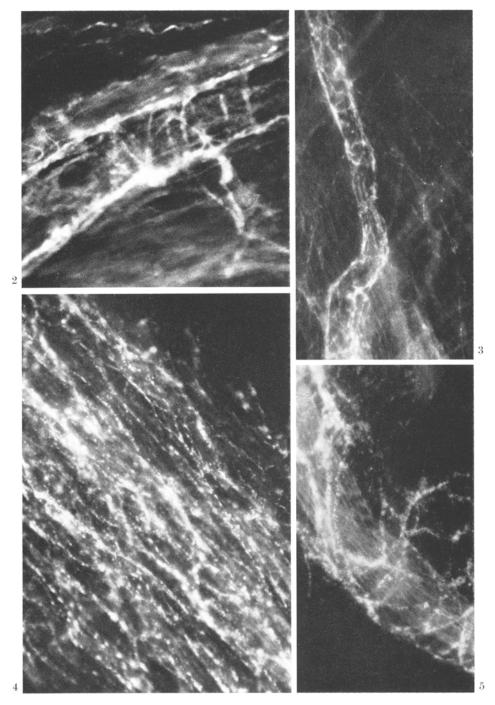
Fluorescing perivascular nerve plexus surrounding arteriole in myocardial tissue. FIF, stretch preparation. $\times 250$. (Female, age 29 years, with uncomplicated ASD of secundum type. Asymptomatic, routine chest x-ray suggestive of ASD. L-R shunt 5.4 l/min. Heart volume 450 cc/m². RR 120/80. No medication)
